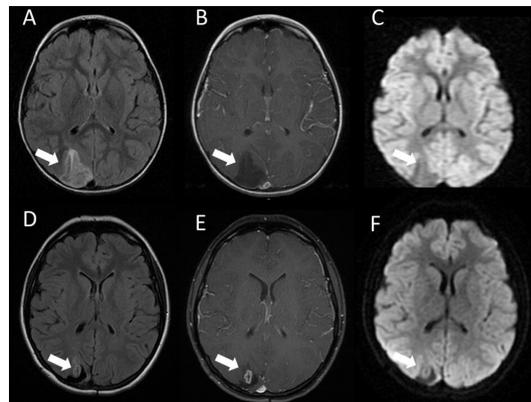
Neuroradiographical features of dysembryoplastic neuroepithelial tumour at initial diagnosis and recurrence 10 years after initial surgery. MRI reveals a right occipital cortical and subcortical tumour (arrow) that is hyperintense on fluid-attenuated inversion recovery (FLAIR) (A), and non-enhancing on post T1-gadolinium weighted sequences (B), and without reduced diffusivity on diffusion-weighted sequences. Ten years post initial gross total resection, neuroimaging reveals a small right occipital tumour recurrence (arrows) on FLAIR sequences (D), with ring-like contrast enhancement on post T1-gadolinium weighed sequences (E), without reduced diffusivity on diffusion weighted sequences (F).
